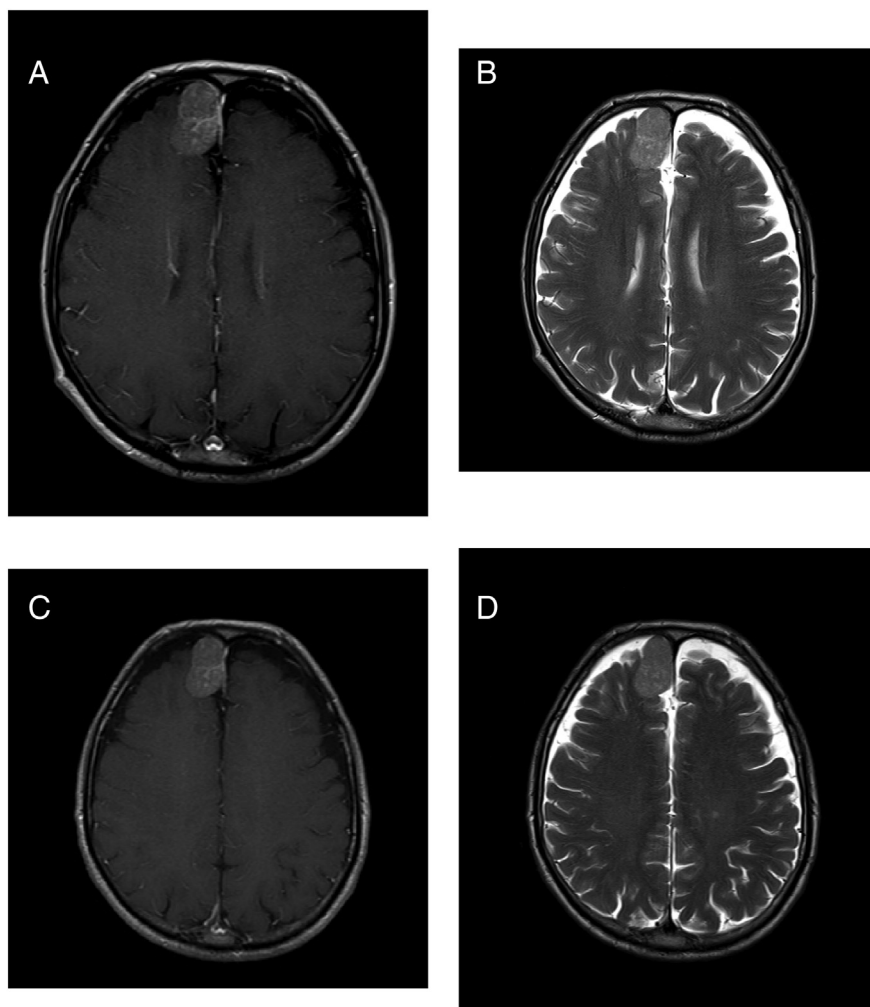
69 year old male patient with frontal meningioma who underwent 6 enhanced brain MRIs with linear GBCA. Axial post-contrast T1 weighted (A), axial pre-contrast T2 weighted images (B) from the first brain MRI and axial post-contrast T1 weighted (C) and axial pre-contrast T2 weighted (D) images from the last brain MRI. The lesion size was measured as 32×21 mm (apxml) on axial T1-weighted image (A) and 32×20 mm on axial T2-weighted image (B) at the initial brain MR imaging. The lesion size was measured as 32×20 mm (apxml) on axial T1-weighted image (C) and 32×20 mm on axial T2-weighted image (D) at the sixth brain MR imaging. The measurements are congruent and there is no progression in the meningioma.
